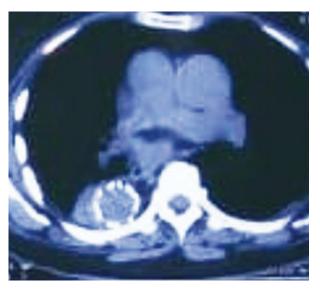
CT scan on the 3rd post-operative day confirms complete exclusion of a ortic ulcer.
